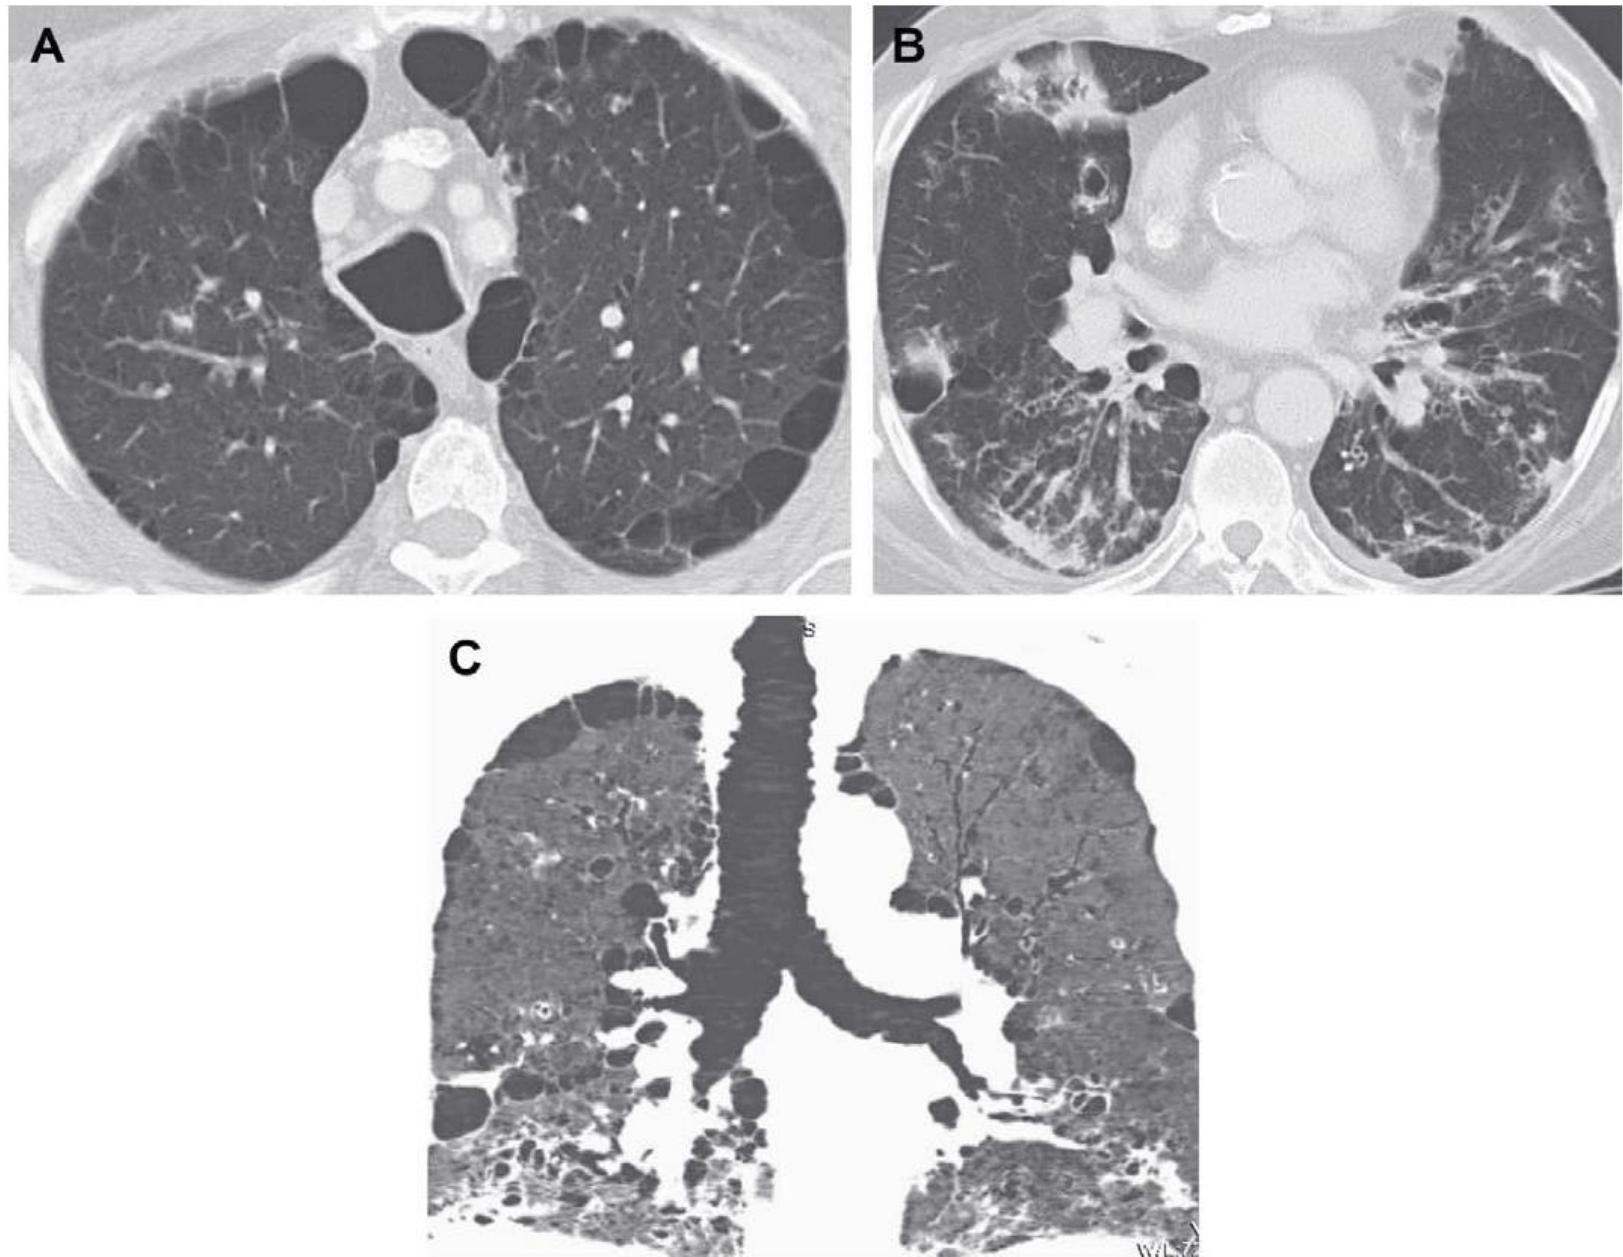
Mounier-Kuhn Syndrome. Transaxial CT images show tracheomegaly (A), and basilar-predominant varicose and cystic bronchiectasis (B) seen in Mounier-Kuhn syndrome. The coronal reconstructed image demonstrates the typical corrugated appearance of the tracheal wall (C).
